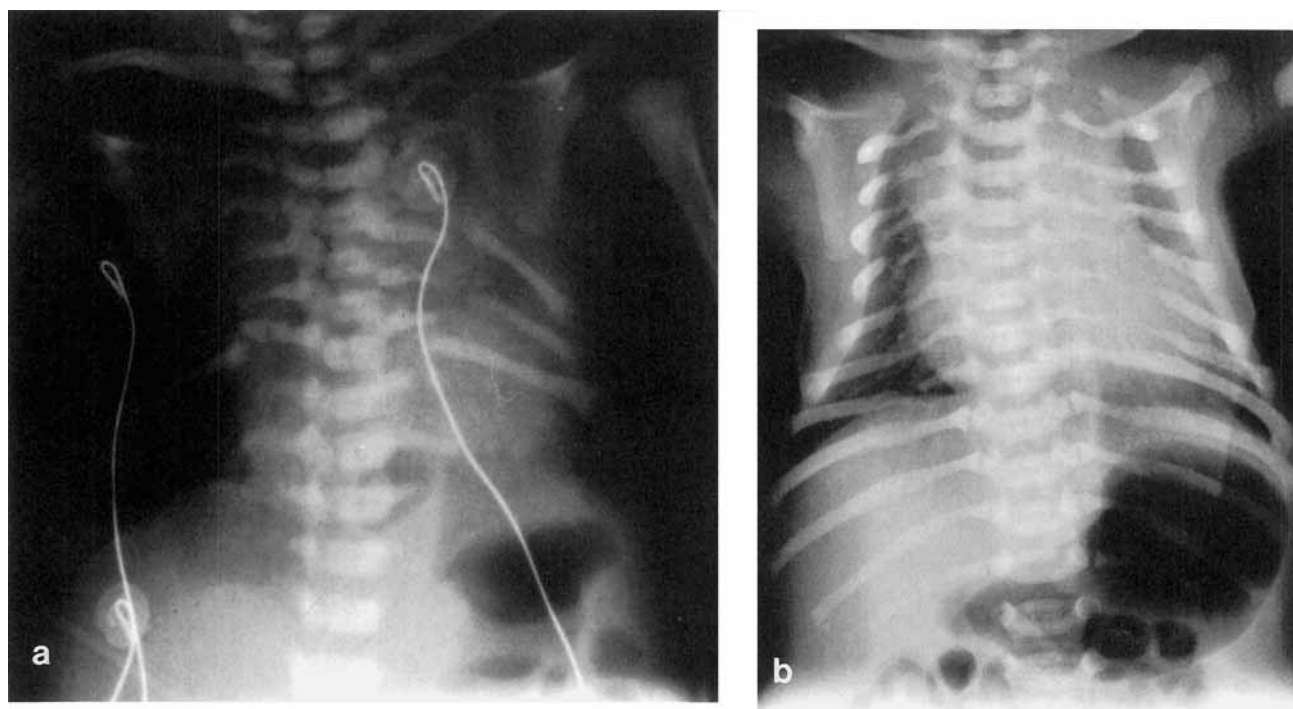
Variability of the rib-gap defects on the chest roentgenographs of patient 1 and 2. a: Patient 1 showed marked hypoplasia of ribs 1–10, multiple posterior rib gaps, and only four ossified ribs: one on the right side and three on the left side. b: Patient 2 showed a bell-shaped small thorax with multiple dorsal rib-gap defects.
